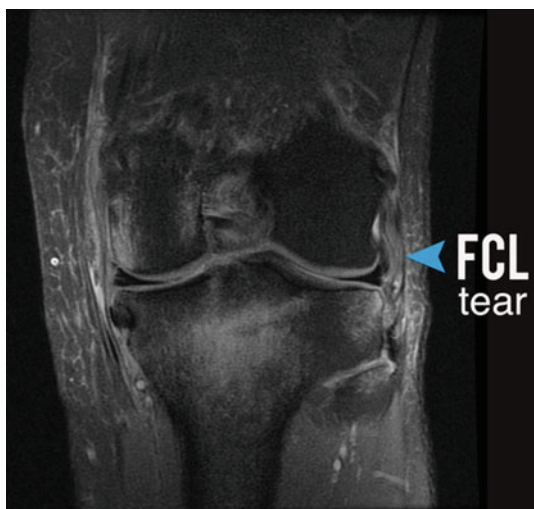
T2-weighted coronal MRI image demonstrating an FCL injury
